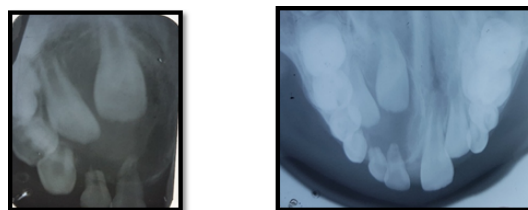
IOPA and cross sectional occlusal radiograph revealed well defined unilocular radiolucency attached at the CEJ of unerupted tooth(11).
